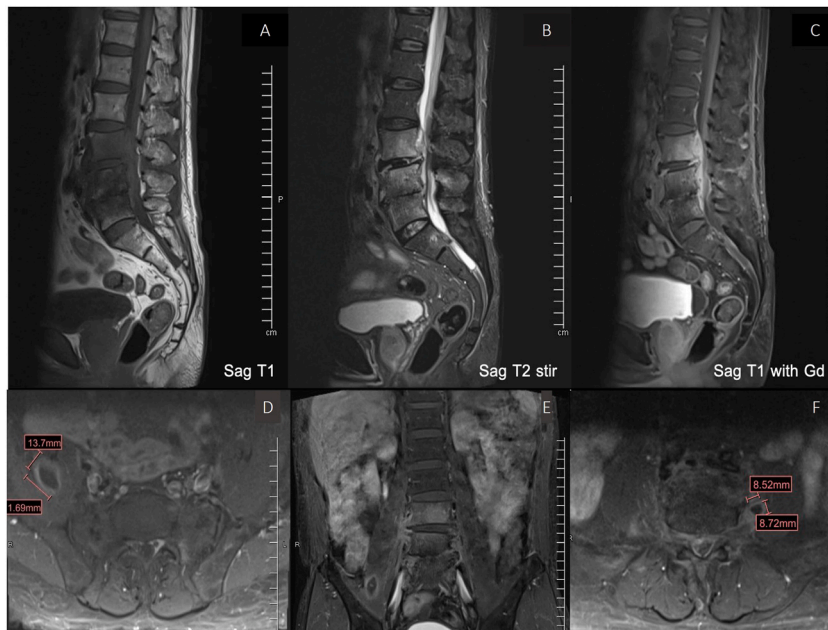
Lumbosacral spine MRI A-C) Spondylodiscitis involvement of L3-S1 vertebra and L3/4 disc with tiny abscess at the L3–L5 ventral epidural space D-F) Rim enhancing abscesses involving the right psoas muscle at the L5/S1 level and left psoas muscle at L4/L5 level measuring 1.4. x1.7 × 2.5-cm and 0.9 × 0.9 × 1.0-cm., respectively.
